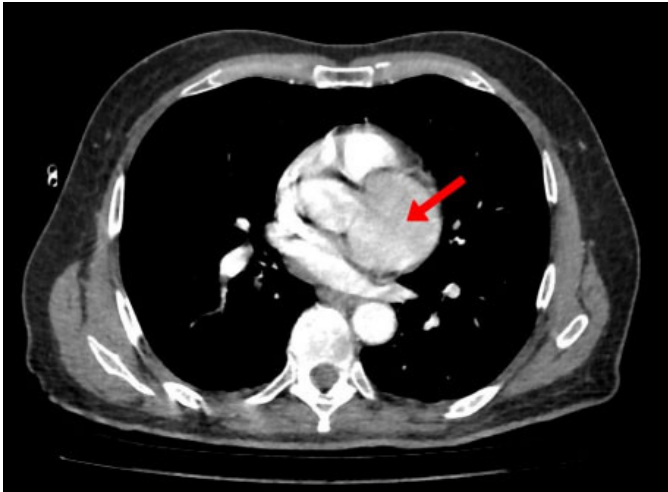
Computed tomography chest angiography. Initially, radiology reported the exam as without any abnormal vascular changes. However, after surgery and image review, a new report suggested a possible aortic aneurysm, pointed by an arrow in the above image.
